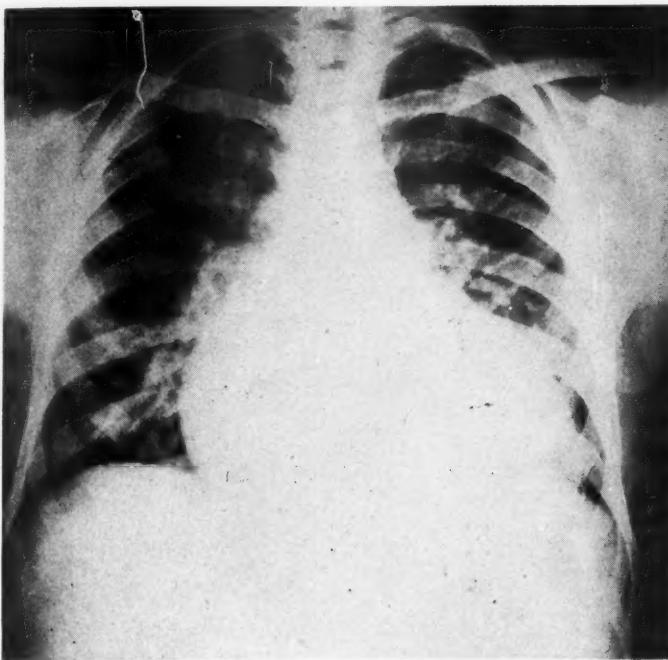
Roentgenogram of the thorax made July, 1943, showing marked cardiac enlargement and bilateral pulmonary passive congestion.
